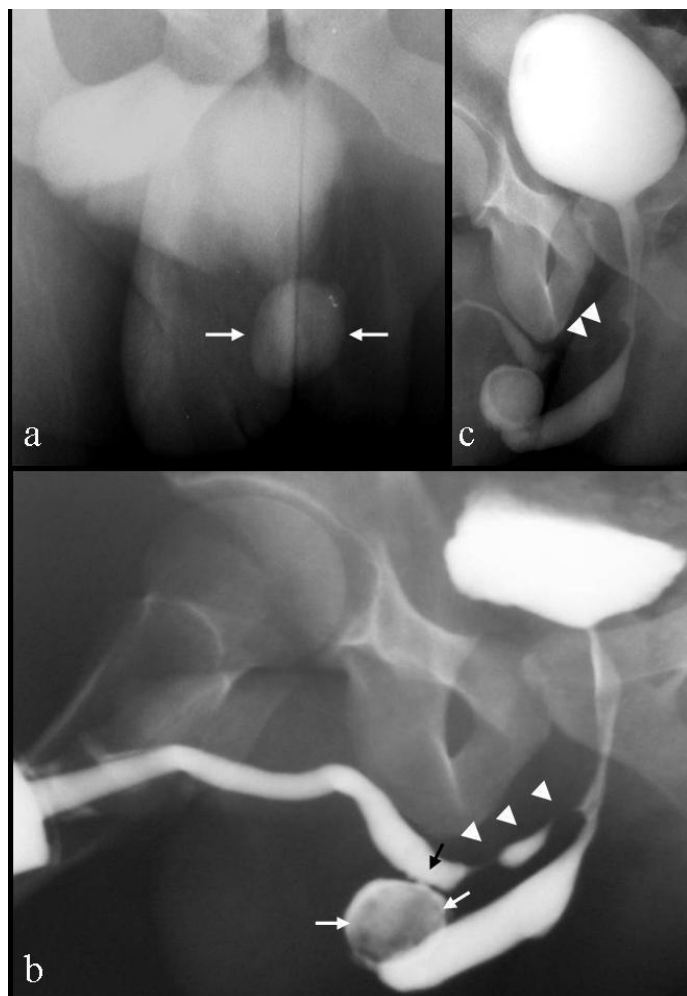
30-year-old male patient presented with difficulty urinating, ejaculatory dysfunction, and a palpable scrotal mass which turned out to be a giant urethral stone. Retrograde urethrogram: (a): control radiograph shows a homogeneously calcified rounded mass projecting over the scrotum (white arrows). (b): during retrograde filling, a long segment stricture is demonstrated at the level of the native bulbous urethra (white arrowheads) and an approximately 20 mm round filling defect, that corresponds to the calcified mass, identified within the reconstructed urethra (white arrows), proximal to a narrowed anastomosis (black arrow). (c): voiding urethrogram shows partial obstruction to urinary flow with disproportionate dilatation of the urethral segments proximal and distal to the stone. Only trace contrast noted across the stricture (white arrowheads).
